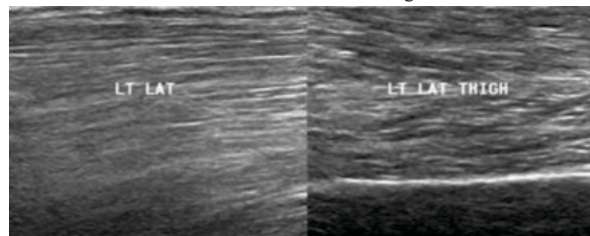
a) ultrasound of the left lateral thigh showing edematous subfascial plane.
